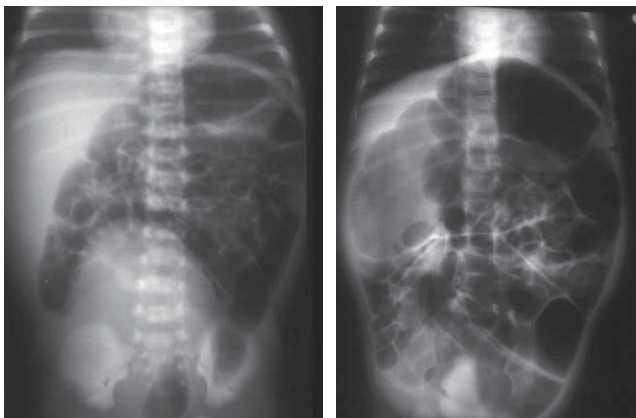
Plain abdominal X-ray of neonatal-onset CIIP. At day 8 after birth (left) and 4 months of age (right), intestinal dilatation is observed. No air-fluid levels are observed due to imaging in the prone position
